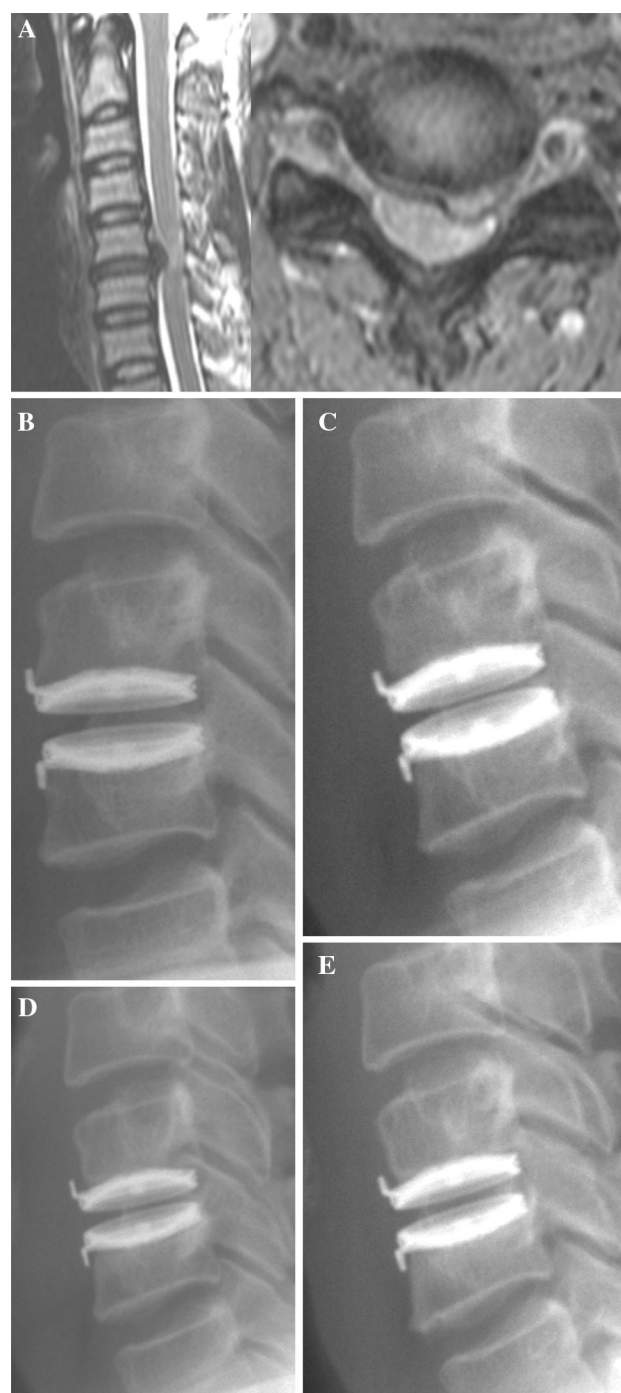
Preoperative magnetic resonance image showing C5–C6 disc herniation (a). Postoperative neutral lateral radiographs showing the prosthesis in normal position 1 month (b) postoperatively, 1.0 mm of bone loss of upper adjacent vertebral body at 3-month follow-up (c), 2.0 mm of bone loss of upper adjacent vertebral body at 6-month follow-up (d), and 2.0 mm of bone loss of upper adjacent vertebral body at 48-month follow-up (e)
